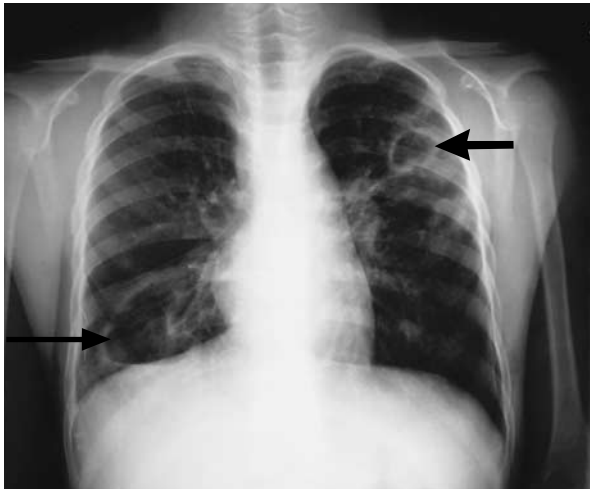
Chest Radiograph of the Source Patient, Showing Cavitory Lesions in the Right Base (Long Arrow) and the Left Upper Lobe (Short Arrow).
